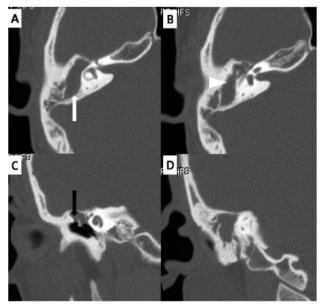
Temporal bone computed tomography. Axial view; A, B: An automastoidectomy state (white arrow)and cholesteatoma in the automastoidectomy cavity and epitympanum (white arrow head). Coronal view; C: Blunted scutum with a widened Prussak space (black arrow). D: Automastoidectomy cavity filled with cholesteatoma.
